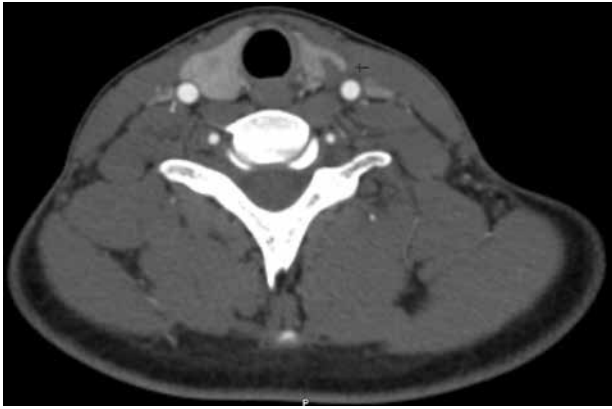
Neck CT showing inflammation of the left lobe of the thyroid gland
